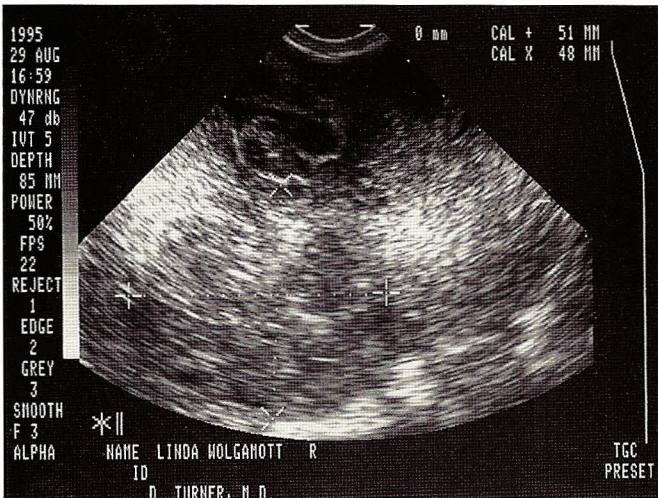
Right-sided pelvic mass adjacent to uterus appears homogenous on transvaginal ultrasound.
